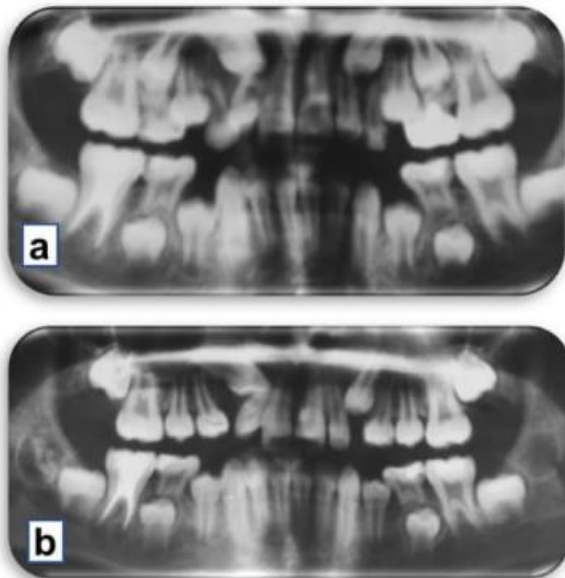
Panoramic radiographs of Case 2 taken 1 year interval.
